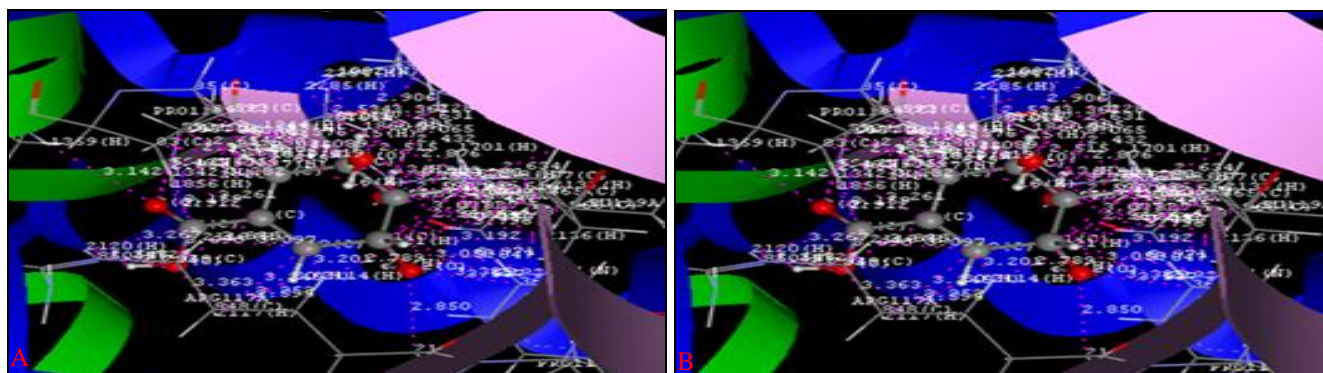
(A) AND 4(B): VANDER WAAL'S INTERACTIONS WITH GLY81, LYS15, ARG58, ARG117, ARG136, PRO11, GLY80, LEU119 IN THE DOCKED MOLECULE OF SHIKIMATE (4A) AND PRO11, LYS15, ARG58, GLY81, GLY80, ARG117, LEU119 IN THE DOCKED MOLECULE OF 4J (4B) IN THE ACTIVE SITE OF SK (PDB CODE: 2IQY) RESPECTIVELY. (SHOWN IN PINK DOTTED LINES)
